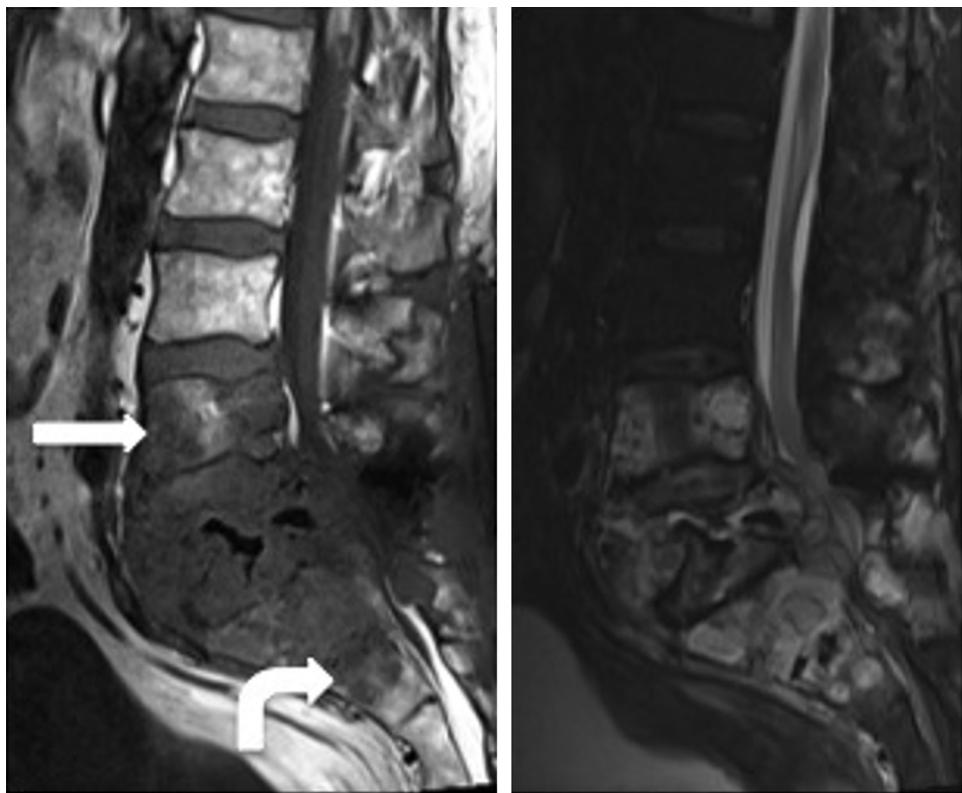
(Left) Sagittal noncontrast T1 images demonstrate extensive hypointense lesion infiltrating L4 (arrow) through S2 (bent arrow). (Right) Sagittal STIR magnetic resonance imaging demonstrates diffuse signal abnormality throughout L4–S2 and involvement of the spinous process of L3.
